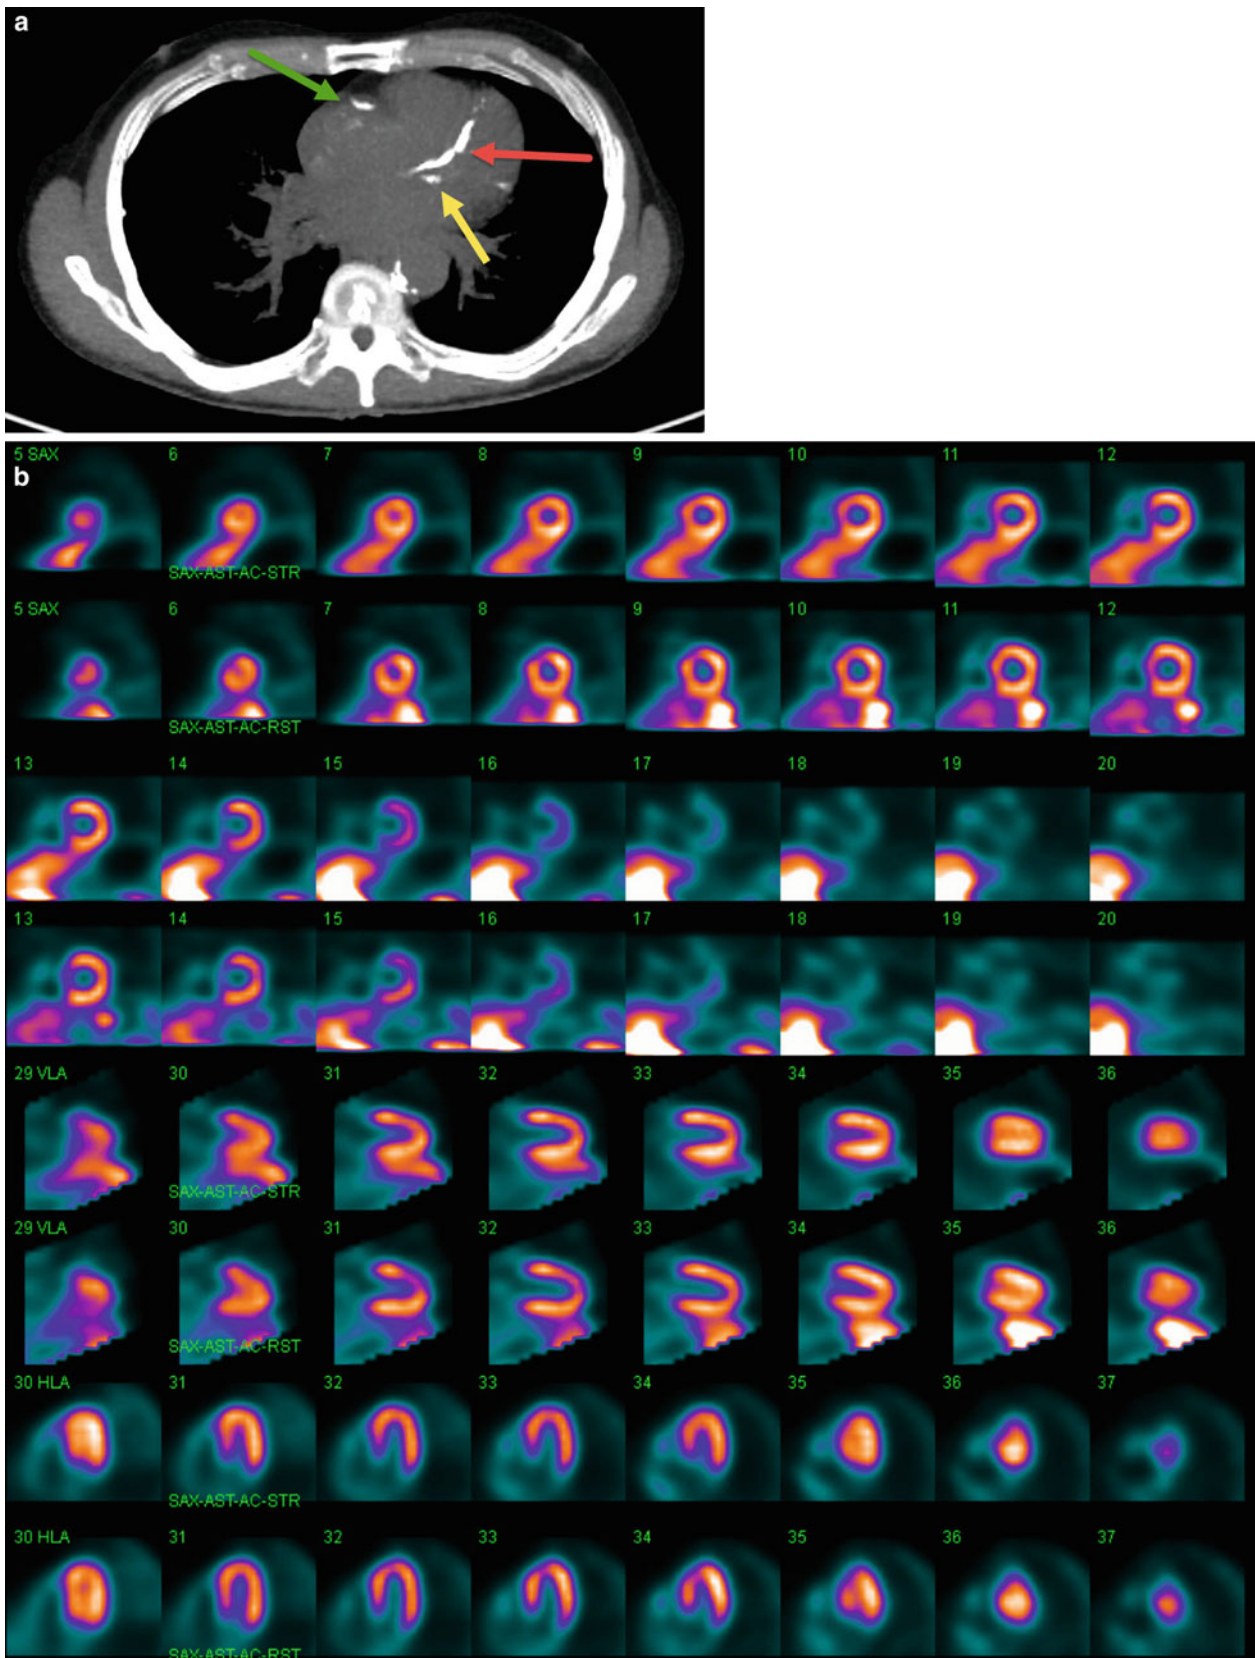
a CT of the chest obtained for oncologic staging as part of an FDG PET/CT study incidentally demonstrates extensive coronary artery calcium in the LAD (red arrow), LCx (yellow arrow) and RCA (green arrow) arteries. The CT images are compressed for better
